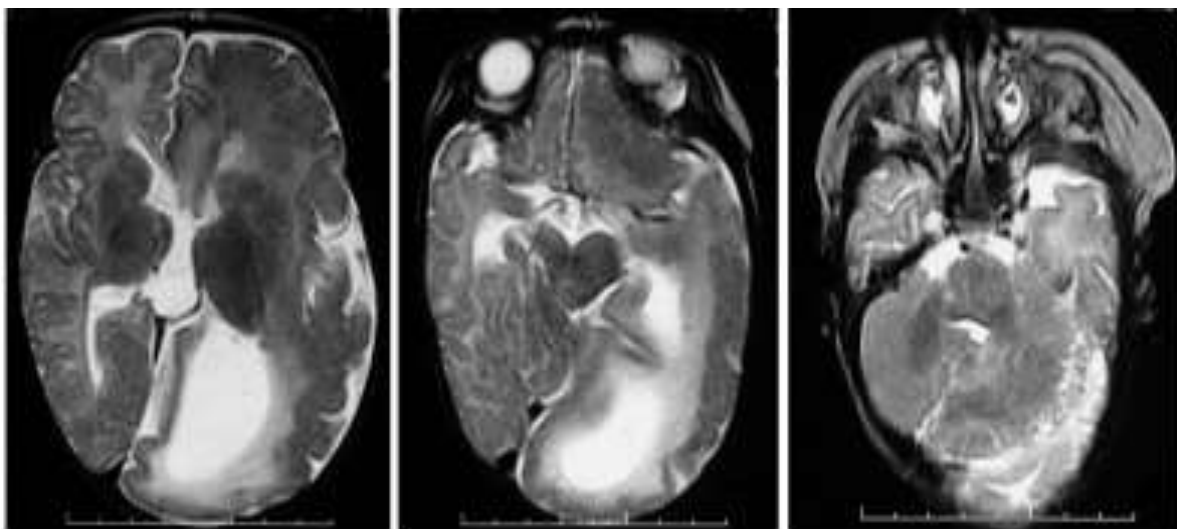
MRI T2 WI axial view revealed several intracranial abnormalities such as hemimegalencephaly with colpocephaly. There was a unilateral hypertrophy of the left cerebral hemisphere, left brain stem, and left cerebellum with thickening of the gyri (pachygyria) and asymmetrical enlargement of the left lateral ventricle. There was also heterotopic grey matter in the basal ganglia of the affected cerebral hemisphere and agenesis of the corpus callosum tail
